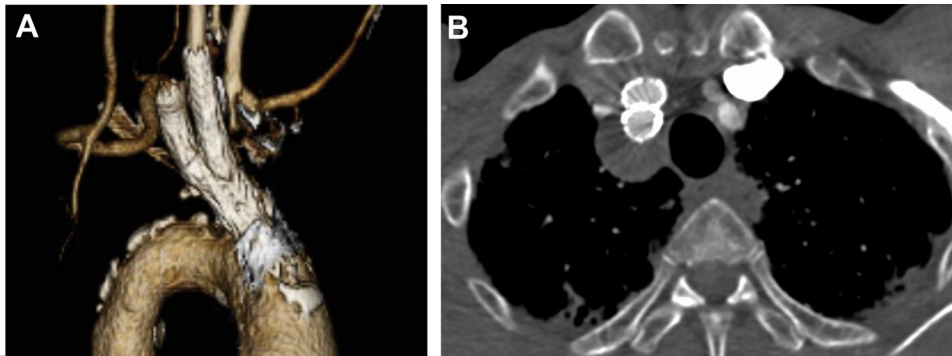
Computed tomography (CT) at 3 months postoperatively. A, Reconstructed three-dimensional image of right oblique view. B, Axial image. These images show the excluded right subclavian artery aneurysm (RSCAA) without stent-graft (SG) fracture.
